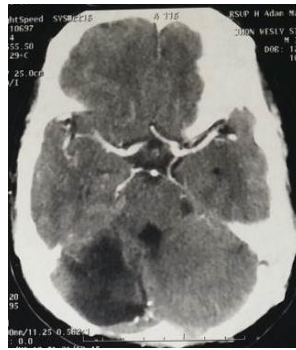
Contrast CT Scan of brain after irradiation shows mixed density at right cerebellum
